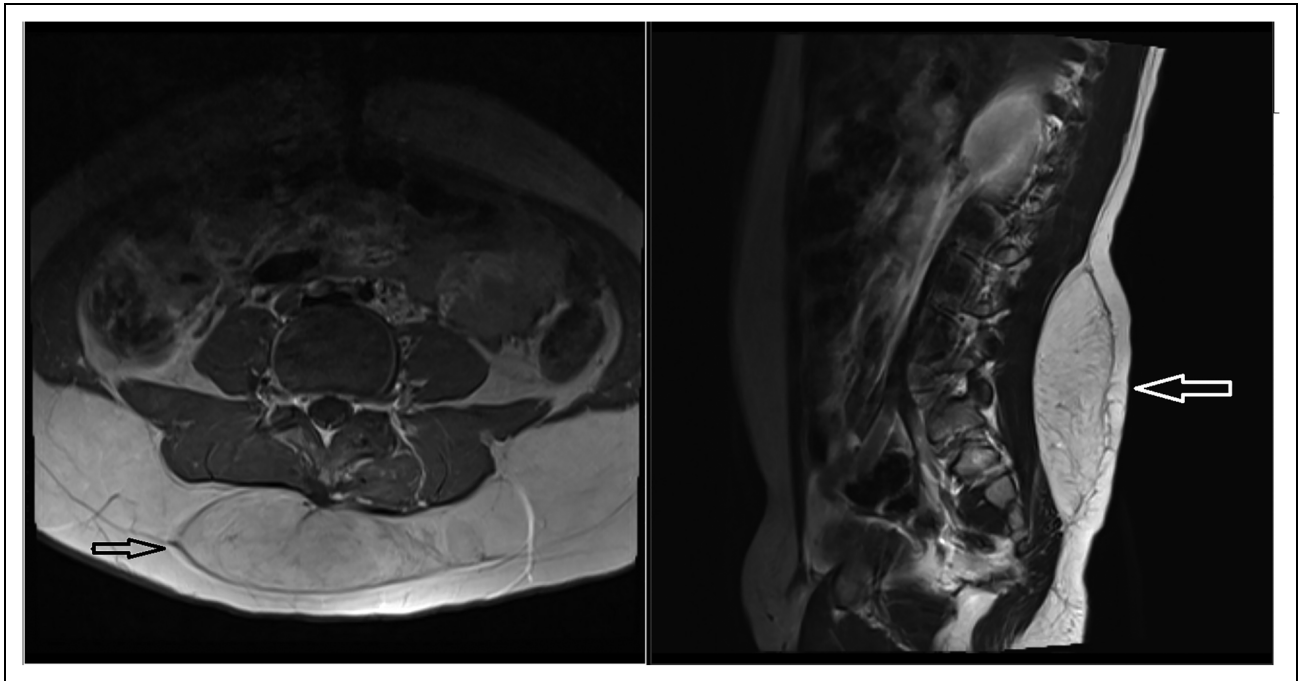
(Patient #3): MRI of the lumbar spine. Axial T1 and sagittal T1 images before liposuction shows large, partially encapsulated fatty soft tissue mass (arrows) with in the deep subcutaneous tissues along the posterior aspect of the lumbar spine and sacrum extending from Lower L2 to the S4 level.
